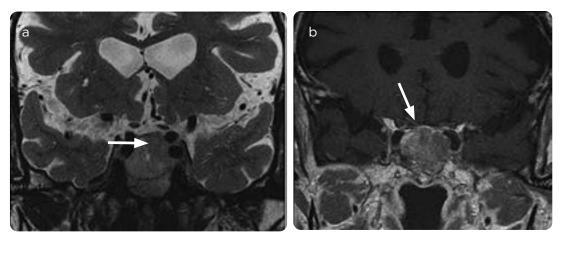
a) MRI, coronal with T2 information: a heterogeneous expansive lesion is observed that occupies and expands the saddle and extends laterally contacting both cavernous sinuses; it corresponds to a pituitary macroadenoma. b) MRI, coronal with T1 information with contrast medium: the lesion highlights the contrast medium in a heterogeneous way (arrows).
